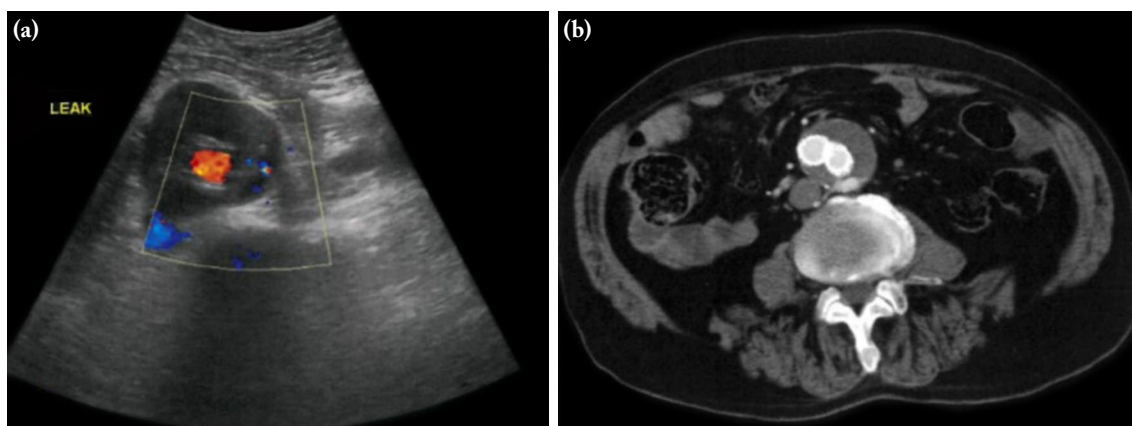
A 80-year-old male patient with type 2 endoleak (No. 4). (a) Axial DUS image demonstrating color coding at the posterior periphery of the sac. (b) Axial CTA image showing contrast filling compatible with type 2 endoleak from the lumbar artery.
